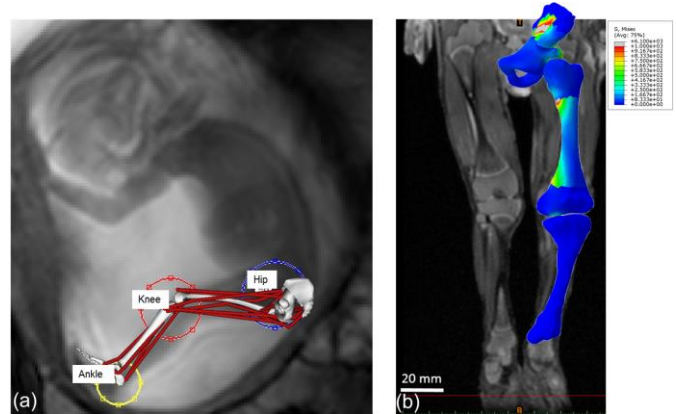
(a) Musculoskeletal model superimposed on a cine-MRI scan of a fetal kick, and (b) the resulting stress stimulation of the lower limb
